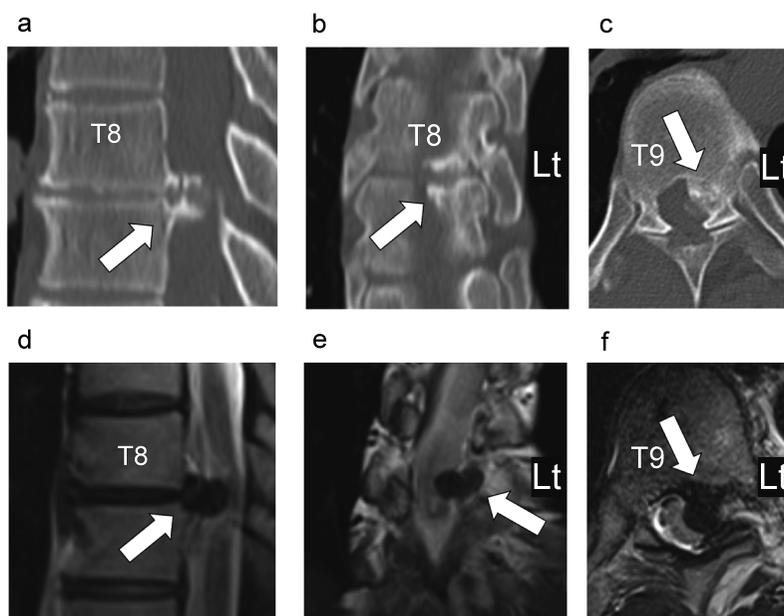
Computed tomography (CT) and magnetic resonance imaging (MRI)
